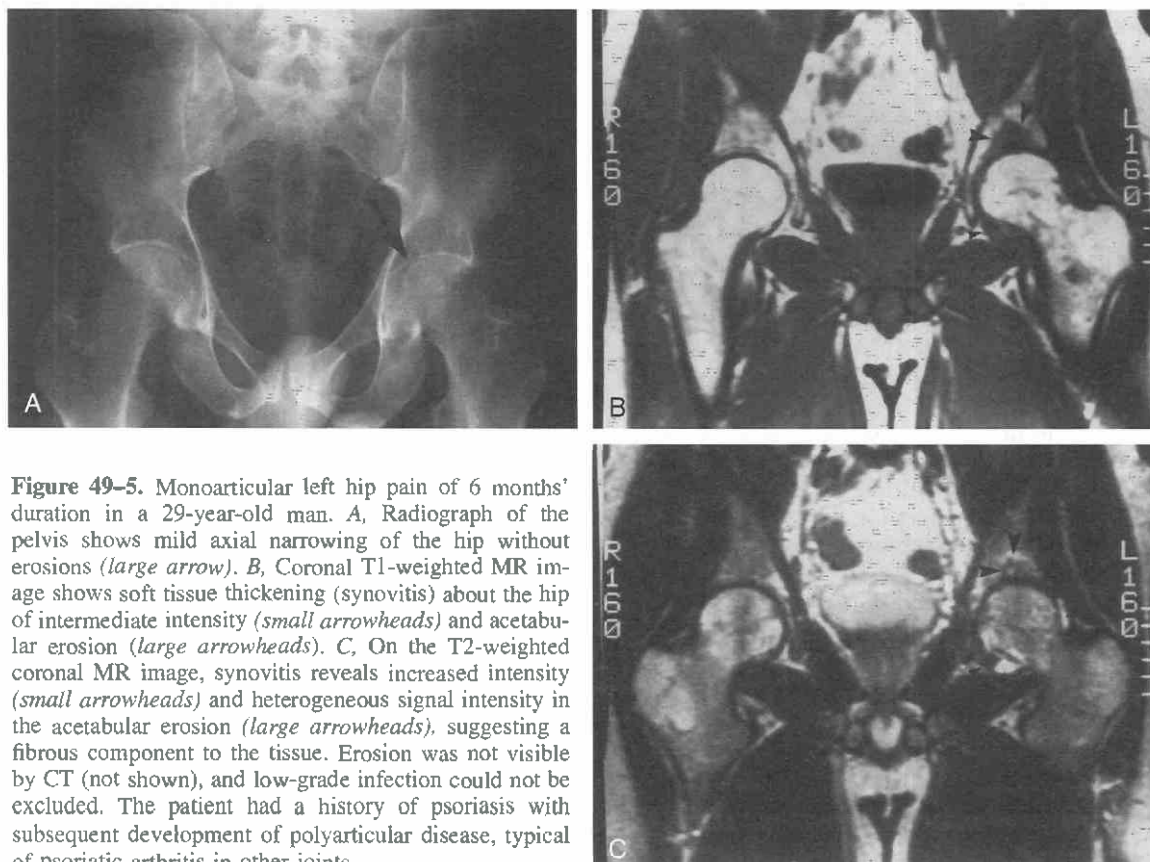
Monoarticular left hip pain of 6 months' duration in a 29-year-old man. A, Radiograph of the pelvis shows mild axial narrowing of the hip without erosions (*large arrow*). B, Coronal T1-weighted MR image shows soft tissue thickening (synovitis) about the hip of intermediate intensity (*small arrowheads*) and acetabular erosion (*large arrowheads*). C, On the T2-weighted coronal MR image, synovitis reveals increased intensity (*small arrowheads*) and heterogeneous signal intensity in the acetabular erosion (*large arrowheads*), suggesting a fibrous component to the tissue. Erosion was not visible by CT (not shown), and low-grade infection could not be excluded. The patient had a history of psoriasis with subsequent development of polyarticular disease, typical of psoriatic arthritis in other joints.
